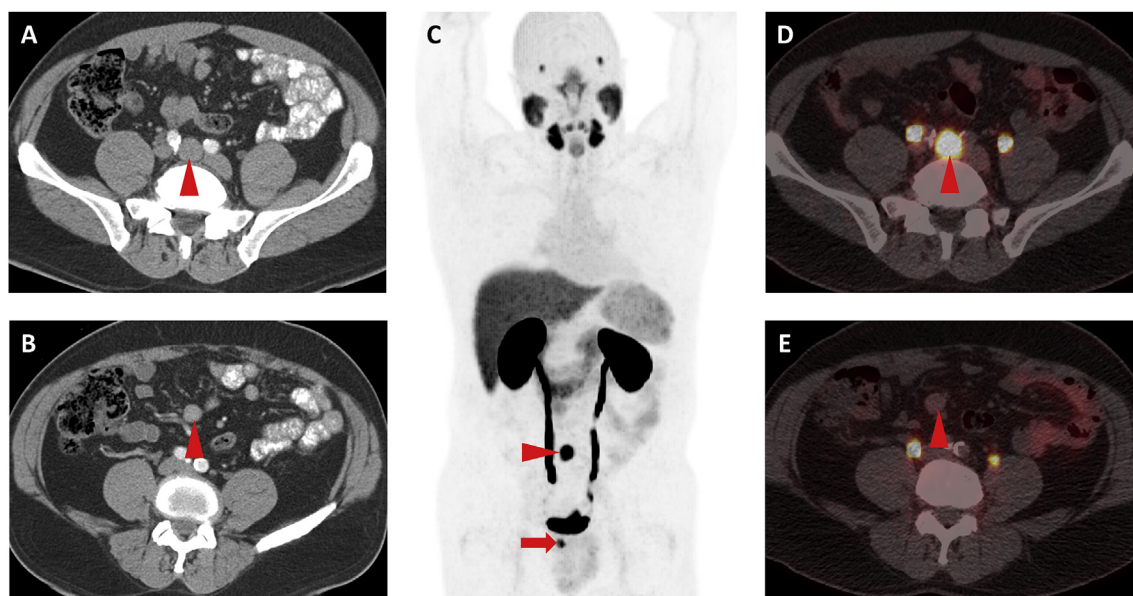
(A) Axial contrast-enhanced CT image through the upper pelvis, inferior to the aortic bifurcation, demonstrating an enlarged (2.0 cm short axis) lymph node between the common iliac vasculature (arrowhead). (B) More superiorly, an axial contrast-enhanced CT image demonstrates mesenteric adenopathy with lymph nodes measuring up to 1.6 cm in short axis (arrowhead). (C) Maximum intensity projection image from a [^{18}F]DCFPyL PSMA-targeted PET study in which the lymph node inferior to the aortic bifurcation shows intense radiotracer uptake (arrowhead) and the patient's primary prostate cancer is also visible (arrow). Although there is overlapping small bowel with normal radiotracer uptake, there is no focal central abdominal uptake to suggest that the mesenteric adenopathy is radiotracer-avid. (D) Axial PET/CT fused image from the [^{18}F]DCFPyL study again showing the intense uptake in the lymph node inferior to the aortic bifurcation (arrowhead). (E) Axial PET/CT image from the [^{18}F]DCFPyL study at the level of the mesenteric adenopathy demonstrates no radiotracer uptake above background (arrowhead).
